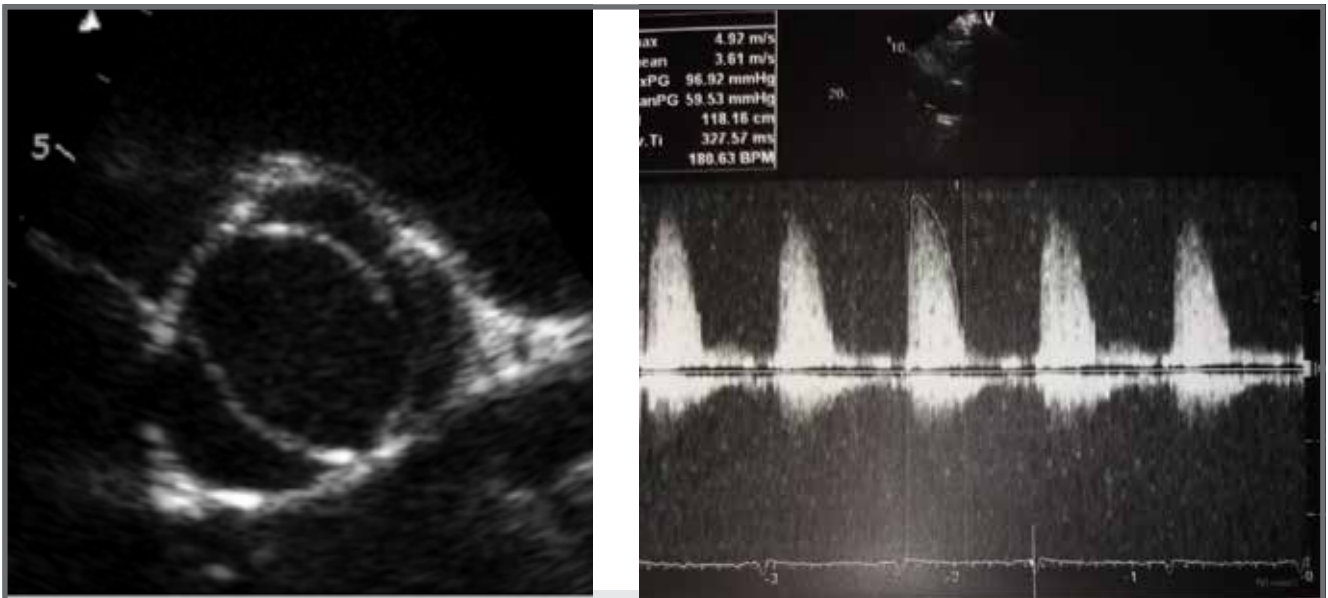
and 2. 2-D and Doppler images of aortic valve and gradient across the valve
